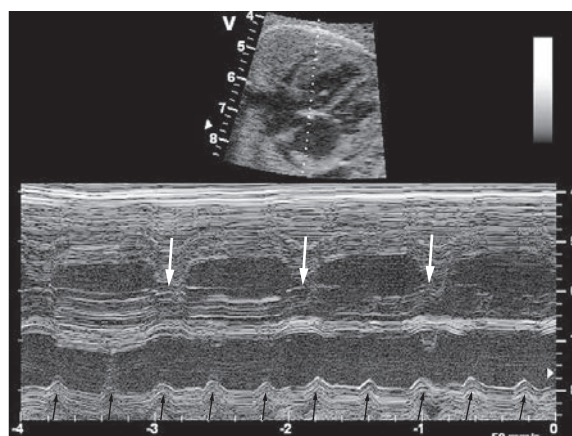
Grade 3 fetal atrioventricular block. Exam during week 25 of pregnancy. Apical 4-chamber view, M-mode depiction of the right ventricle (top) and left atrium (bottom). Independent atrial (thin arrows) and ventricular contractions (thick arrows) with an atrial frequency of 150/minute and a ventricular frequency of 60/minute. (With the gracious approval of Dr. V. Tomek, Children's Heart Centre Prague, University Hospital in Motol, Czech Republic.)
